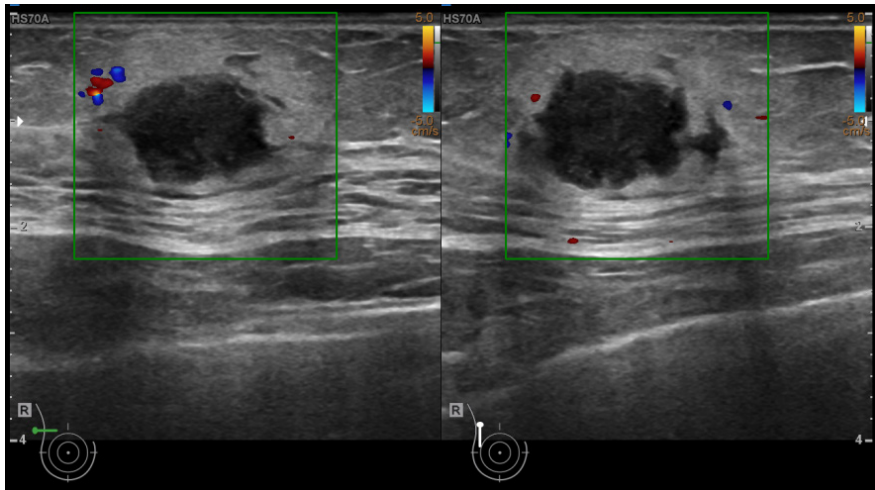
Ultrasonography showed a spiculated hypoechoic mass in the upper outer quadrant of the right breast, about 1.1x1.5x1.9 cm in size.
